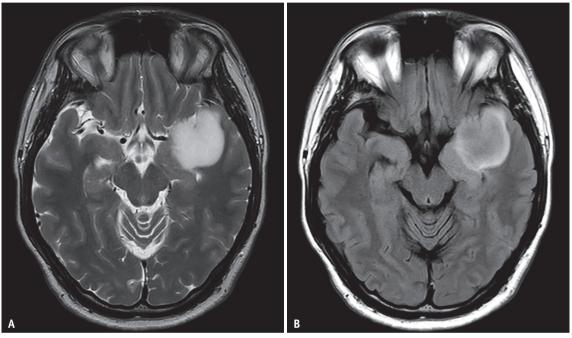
A 32-year-old male with diffuse astrocytoma, isocitrate dehydrogenase-mutant, showing T2-FLAIR mismatch sign.
